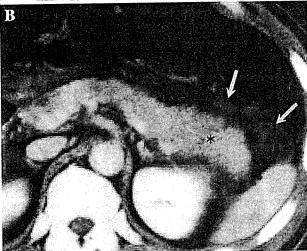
Acute edematous pancreatitis. Observed are enlargement of the tail of the pancreatic body (a case 1; asterisks) and enlargement of the pancreatic tail (b case 2; asterisks). It was thought that the evenly visualized tail of the pancreatic body and pancreatic tail shown by contrast-enhanced computed tomography (CT) in both cases suggested the presence of edematous pancreatitis, An increased density of adipose tissue in the parapancreatic tissue (arrows in a, b) shows the extension of inflammation as far as the parapancreatic tissue in both cases
